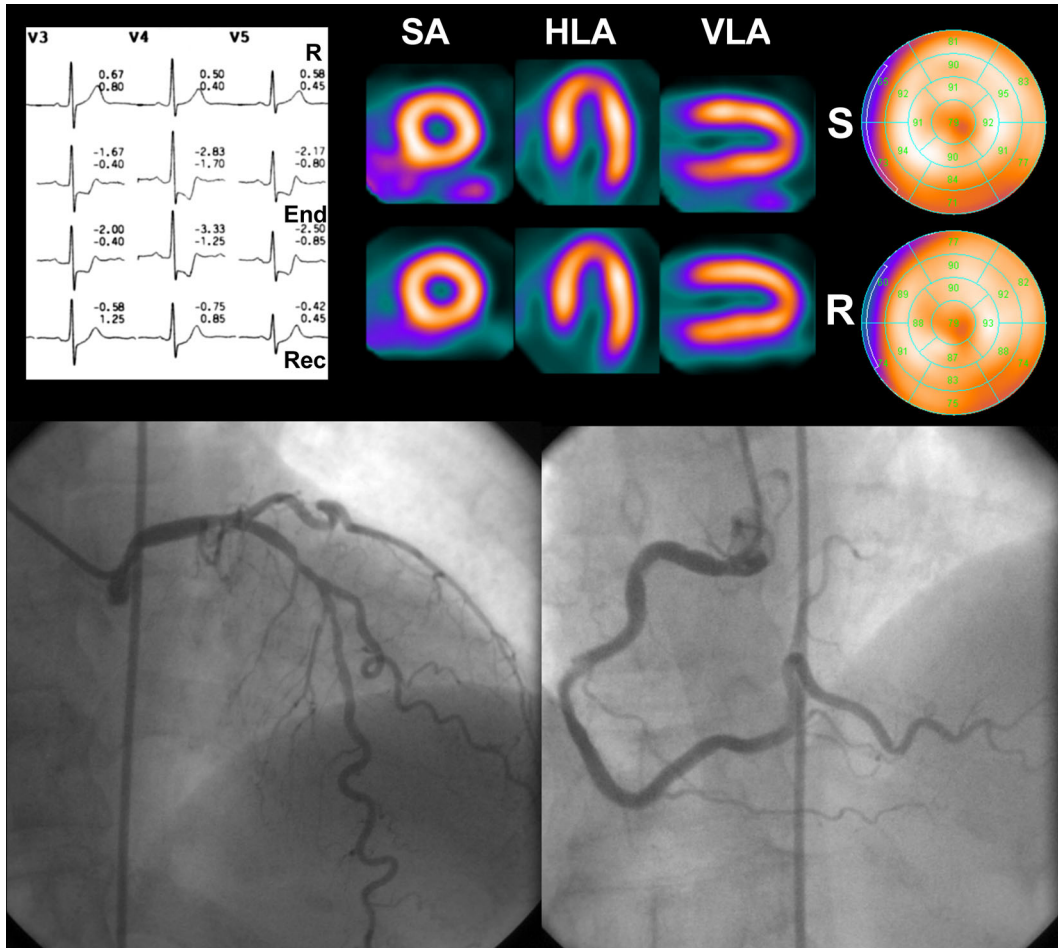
Normal myocardial perfusion SPECT of a man with downsloping ST-segment depression at the end of exercise of exercise test, and moderate stenoses of left main, left anterior descending, left circumflex, and right coronary arteries. *HLA* Horizontal long axis; *R* rest; *Rec* recovery; *S* stress; *SA* short axis; *VLA* vertical long axis.
